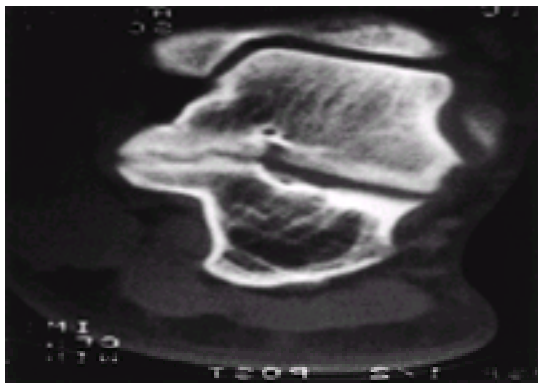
Computed tomography scan is the best imaging tool to diagnose tarsal coalitions, and here reveals one in the medial portion of the subtalar joint.
